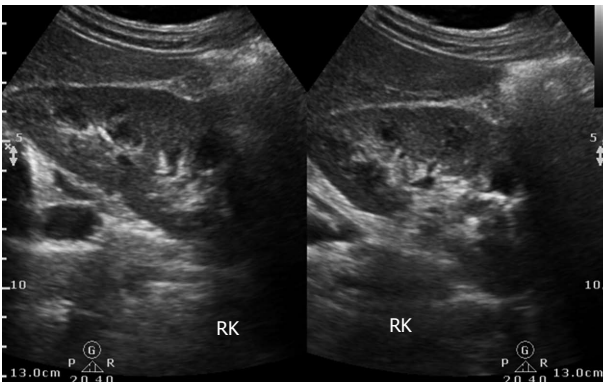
Follow up ultrasound revealed normal right kidney.
